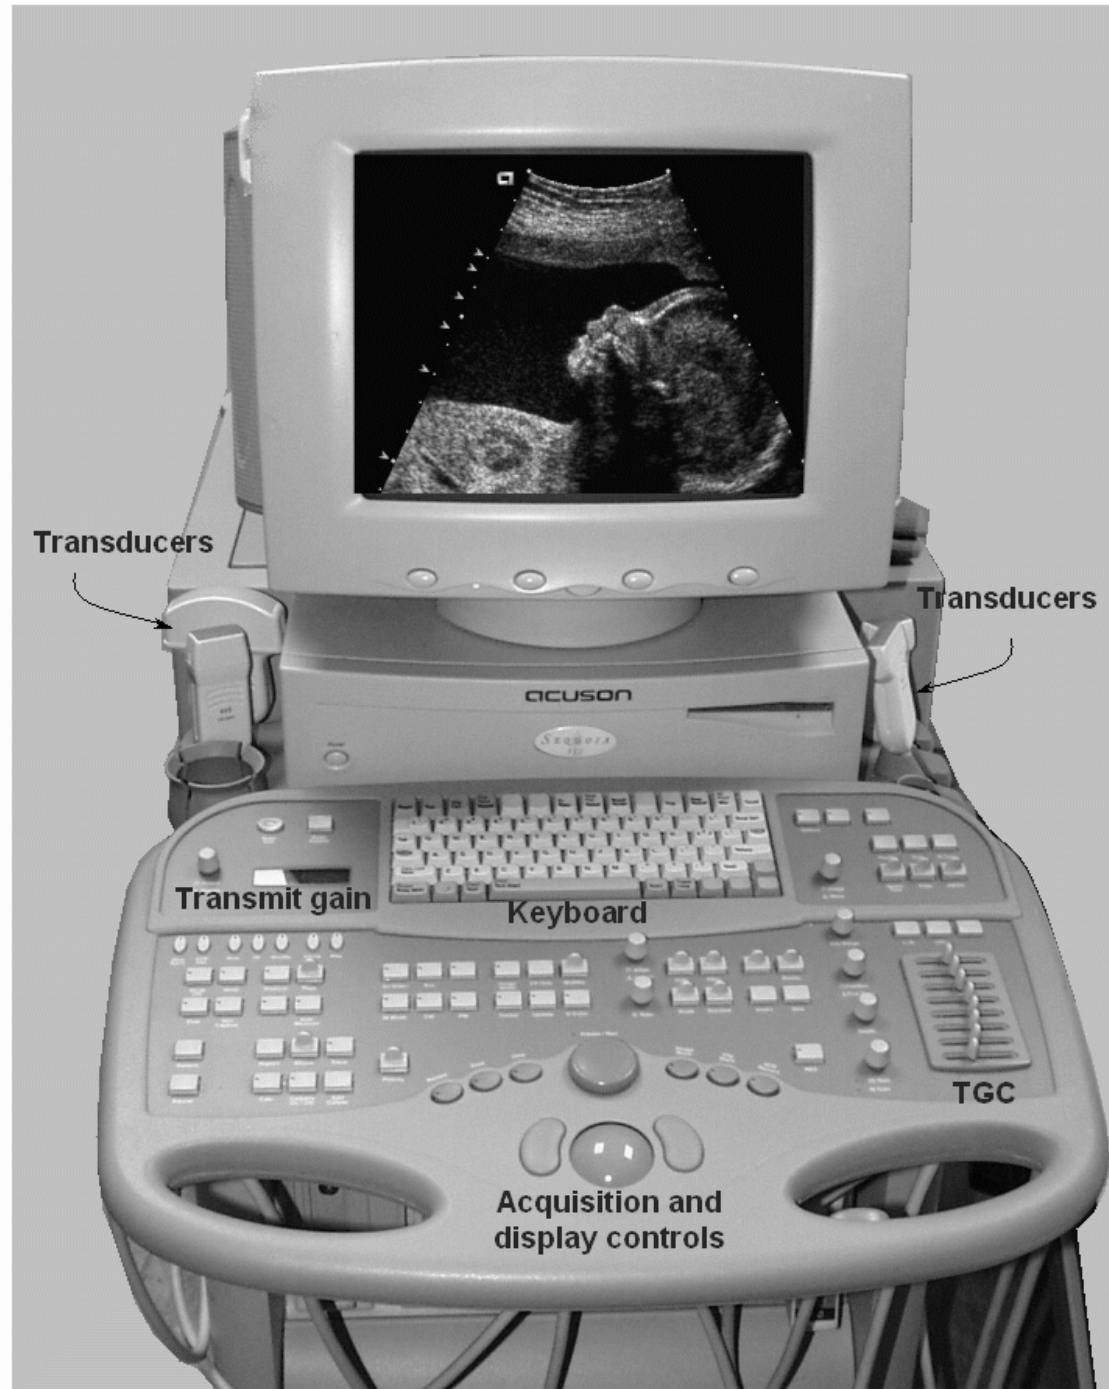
A commercial ultrasound scanner system is composed of a keyboard, various transducer selections, an image display monitor, and other components/interfaces.
